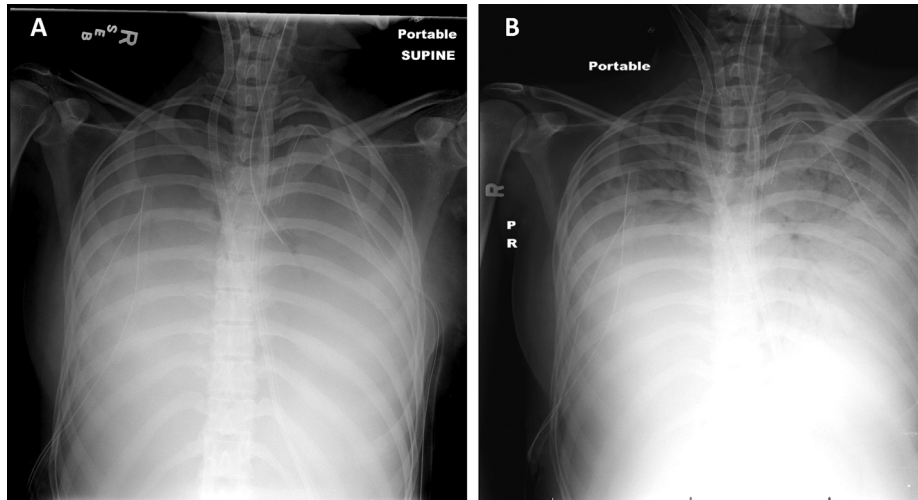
Chest X-rays obtained prior to pulmonary lavage with PFD (A) and following suctioning of PFD, thrombus and approximately 24 h of recruitment with high-frequency oscillatory ventilation (B). There is interval improvement in aeration and new air bronchograms consistent with clot removal. PFD, perflurodecalin.
